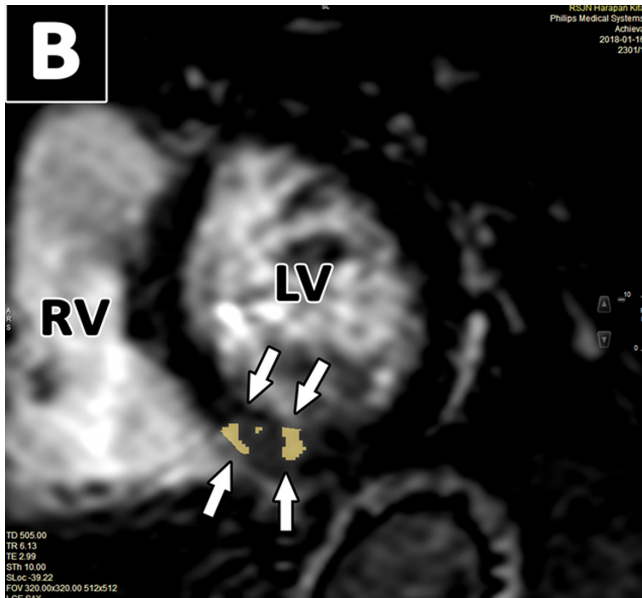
Late gadolinium enhancement protocol in cardiac magnetic resonance imaging analysis from different patients with rheumatic mitral stenosis
